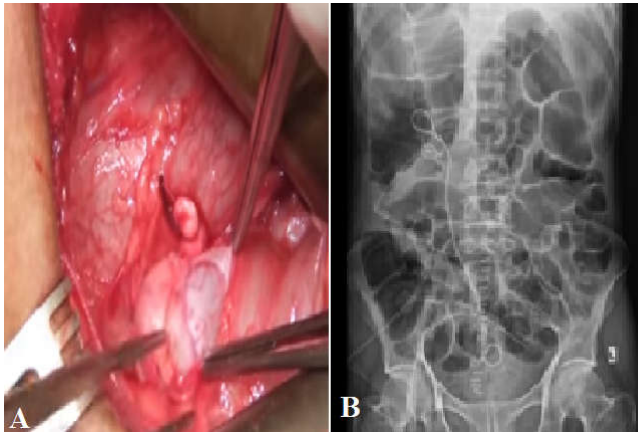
(A) Intra operative transected distal ureter and bladder. (B) Postoperative X-ray KUB with DJ stent insitu.
